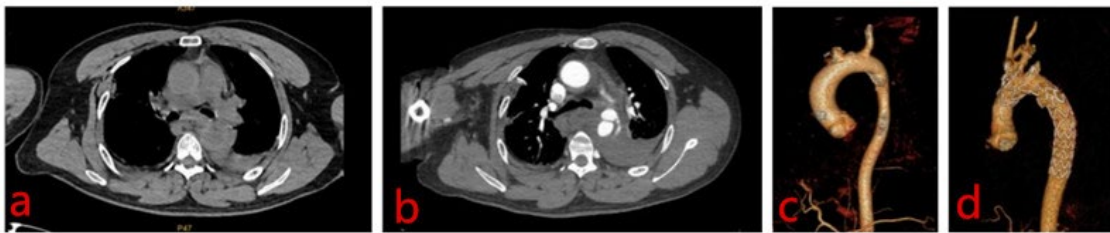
a. CT showed a widened aortic shadow with unclear boundary; b. Contrast-enhanced CT scan showed aortic dissection; c. CTA showed that the rupture was located adjacent to the aortic arch near the descending aorta; d. CTA at one month following the operation showed that the metal stent was unobstructed and in proper position, with no significant contrast agent exudation, and a few atherosclerotic plaques in the aorta and iliac artery.
